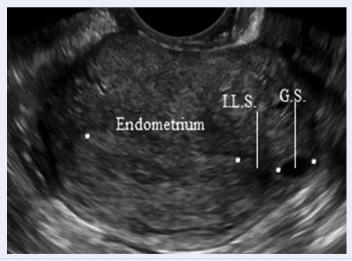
An ultrasound image shows an eccentric gestational sac (GS) > 1 cm away from the lateral endometrial edge and the interstitial line sign (ILS) as an echogenic line extending from the eccentric GS to the endometrial line
